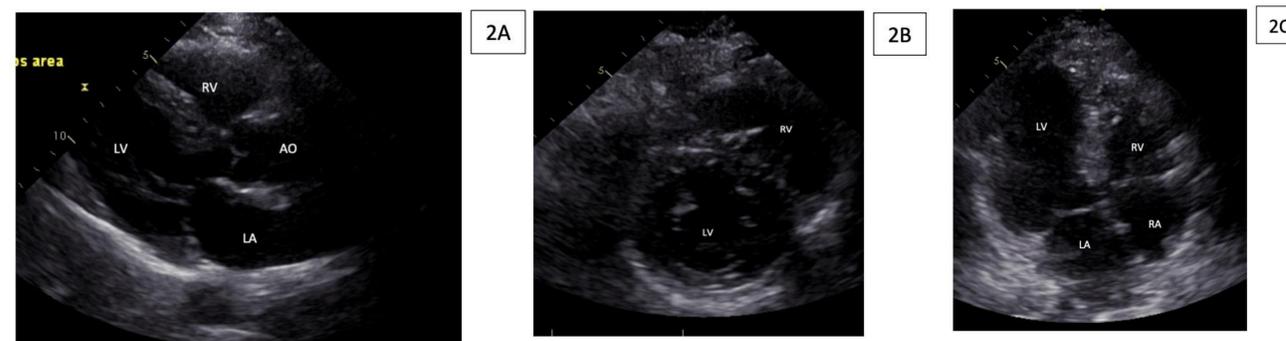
Transthoracic echocardiogram revealing situs inversus with dextrocardia (LV= left ventricle, LA = left atrium, RA = right atrium, RV = right ventricle, AO = aorta).
